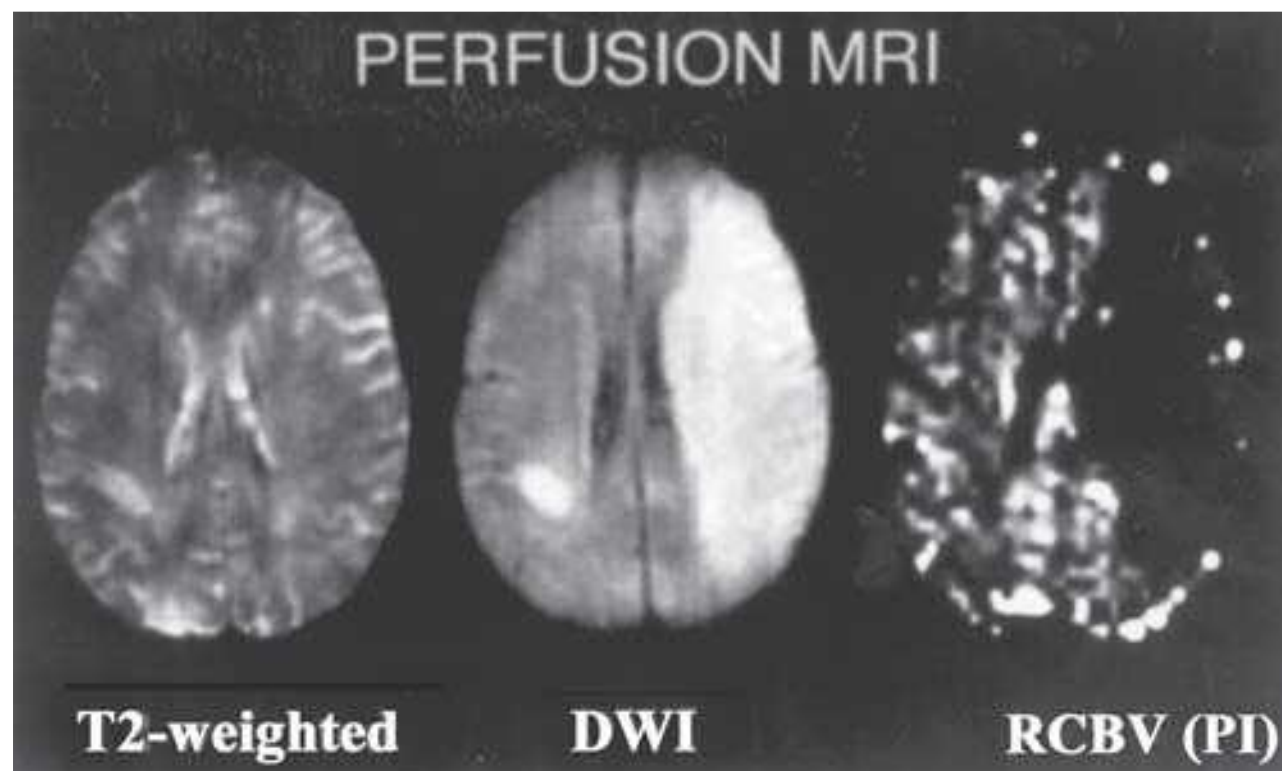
Magnetic resonance image of the brain with T2-weighted imaging, diffusion-weighted imaging (DWI), and perfusion imaging (PI) in a patient with acute ischemic stroke. Although T2 reveals very little change, there is a large DWI hyperintensity corresponding to a PI deficit (DWI-PI mismatch), demonstrating a completed infarct and a situation in which recombinant tissue plasminogen activator is not indicated. RCBV, regional cerebral blood volume.
